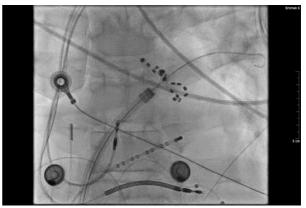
Anteroposterior x-ray projection of Farawave catheter in left pulmonary veins in patient with implanted ICD.
